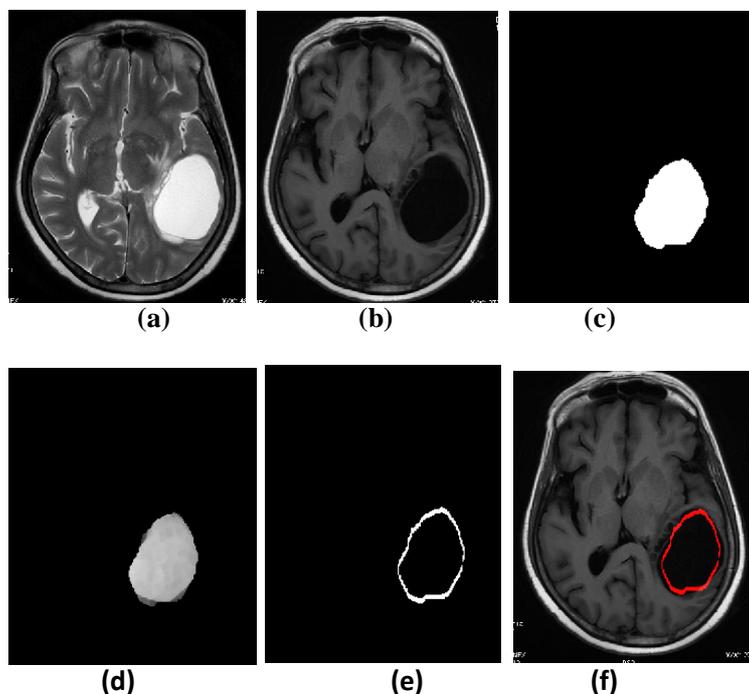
The example for development of tumor segmentation and Boundary Extraction techniques. (a) & (b) Axial slices of T2 weighted and T1 FLAIR image in a patient image dataset. (c) Segmented binary tumor (d) Segmented Gray level tumor (e) Tumor boundary (f) Extracted boundary is superimposed T1 FLAIR image.
